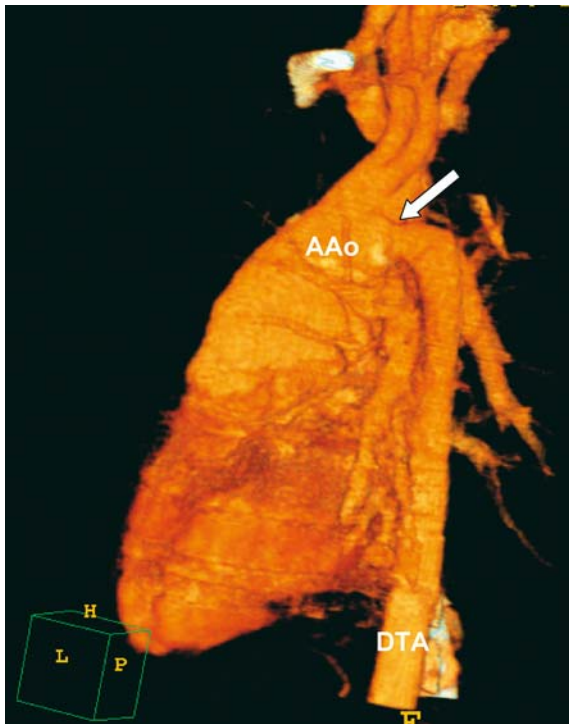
Aortic arch interruption: status post repair. CT scan in the same patient of Fig. 3.14.1 with left oblique posterior sagittal view, volume rendering imaging, showing the end-to-side anastomosis (arrow) used to reconstruct the aortic arch continuity one year after surgery (AAo ascending aorta, DTA descending thoracic aorta) (photograph courtesy of Dr. Mohammed Tawil)
